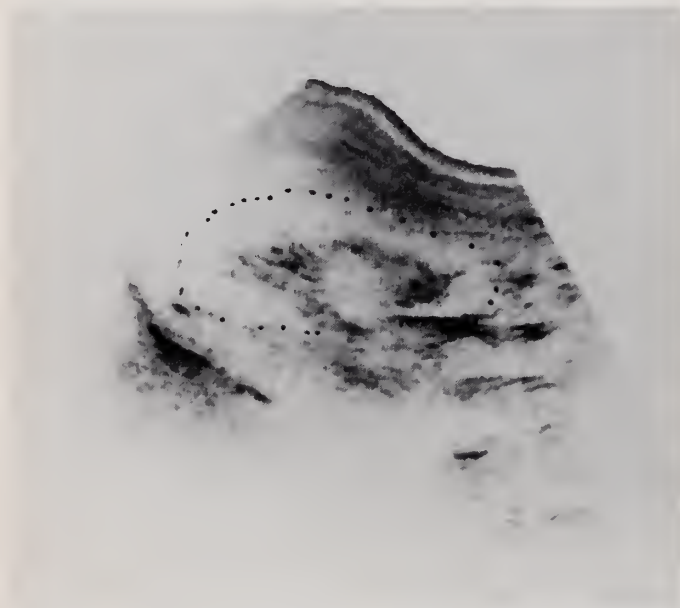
Sonography right kidney, longitudinal section.
